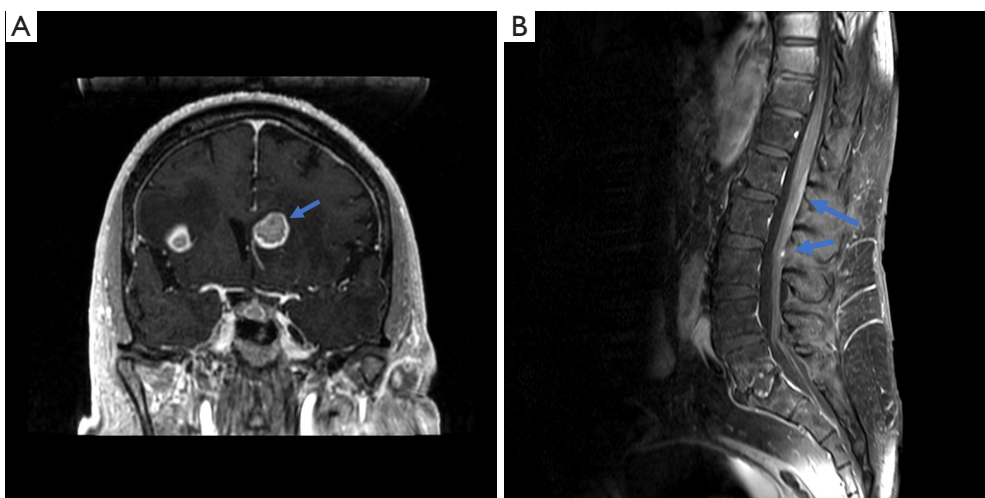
Central nervous system metastases identified on imaging for case 2. (A) MRI of left caudate head lesion extending to the ependymal surface of the left frontal horn (T1) (blue arrow denotes lesion). (B) MRI of spine demonstrating enhancement along intradural nerve roots and cauda equina (T1) (blue arrows specify areas of enhancement). MRI, magnetic resonance imaging.
